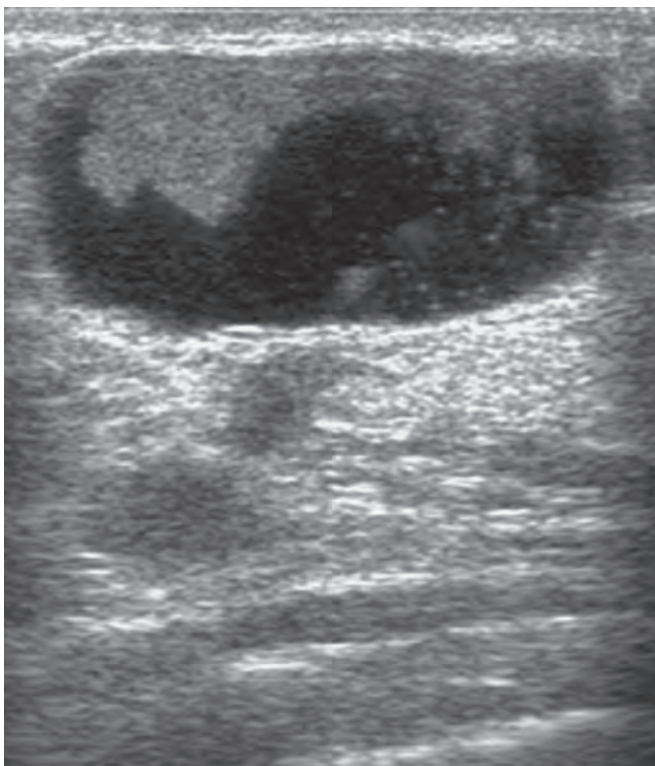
Ultrasound of an intraduct papilloma characteristic of those seen in multiple papilloma syndrome—such lesions can be excised by mammotomy.
